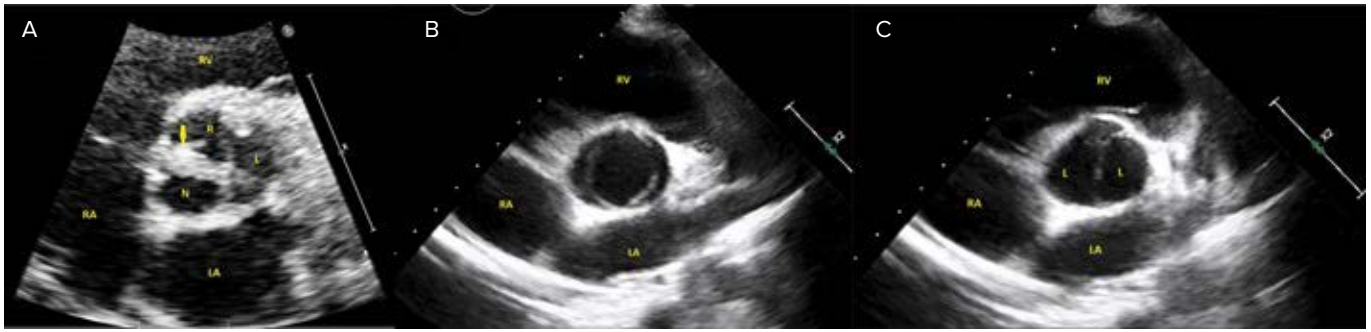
Transthoracic echocardiogram parasternal short axis view. A. Diastolic view of BAV with raphe (arrow), phenotype 1B (right–noncoronary cusp fusion). L, left coronary cusp; LA, left atrium; N, noncoronary cusp; R, right coronary cusp; RA, right atrium; RV, right ventricle. B. Systolic view of phenotype 0 (no raphe) BAV. C. Diastolic view of phenotype 0 (no raphe) BAV. L, leaflet.
